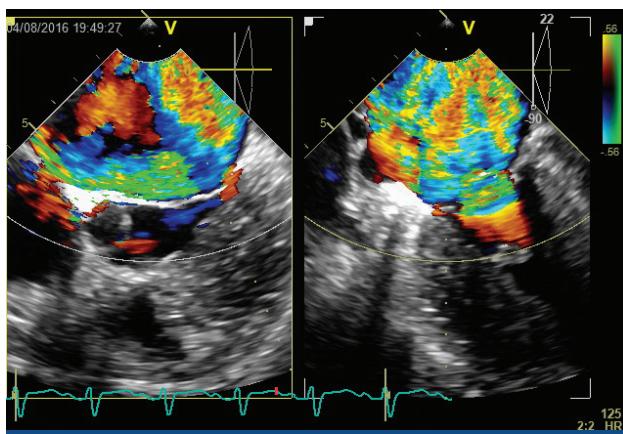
Multiplane transesophageal echocardiogram showing massive, highly eccentric anterior mitral regurgitation jet.
